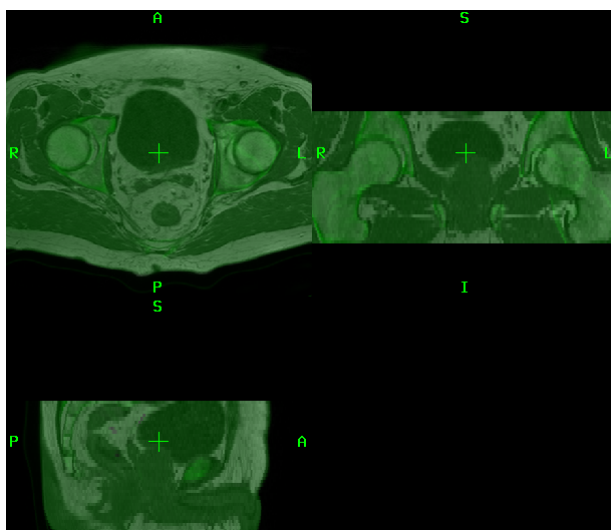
CT registration.
